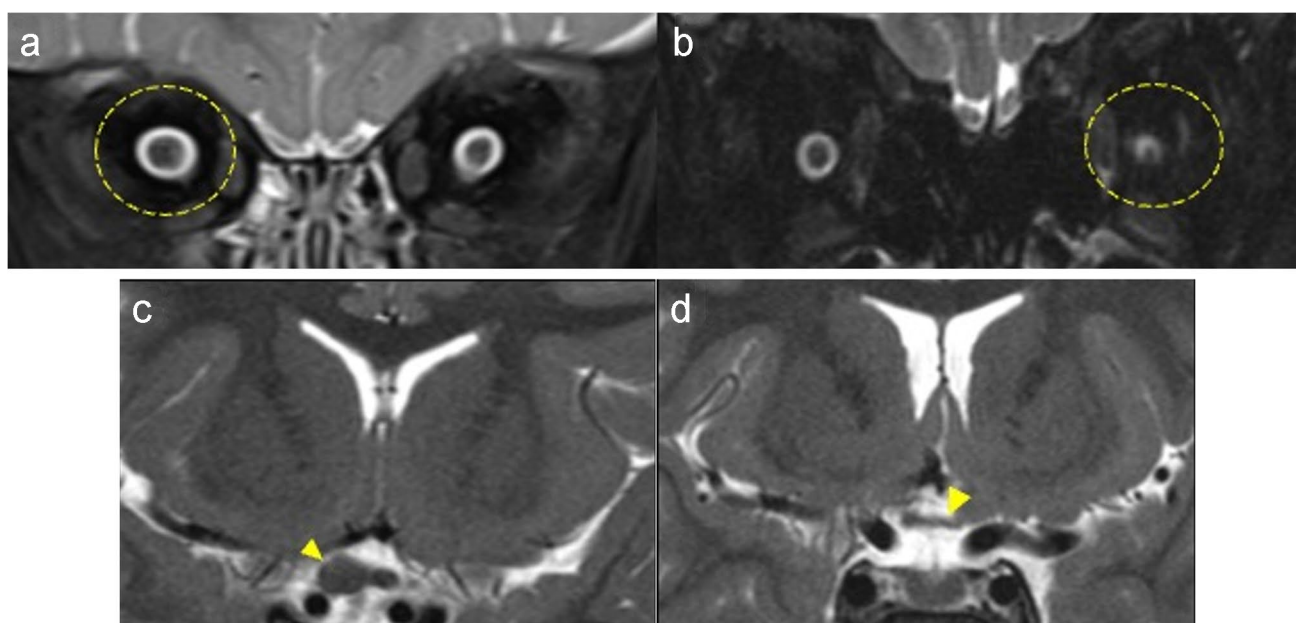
a Coronal high-resolution, T2-weighted, fat-saturated imaging of the orbits in an 11 month old girl with right MGDA diagnosed fundoscopically demonstrates a normal left and abnormal, thickened right intraorbital optic nerve (dashed circle). Note homogenous T2 signal within the enlarged right intraorbital optic nerve; there was no associated enhancement nor progression on 6 month follow-up MRI. b Coronal high-resolution, T2-weighted, fat-saturated imaging of the orbits in a 7 year 10 month old girl with left MGDA diagnosed fundoscopically demonstrates a normal right and abnormal, thinned
